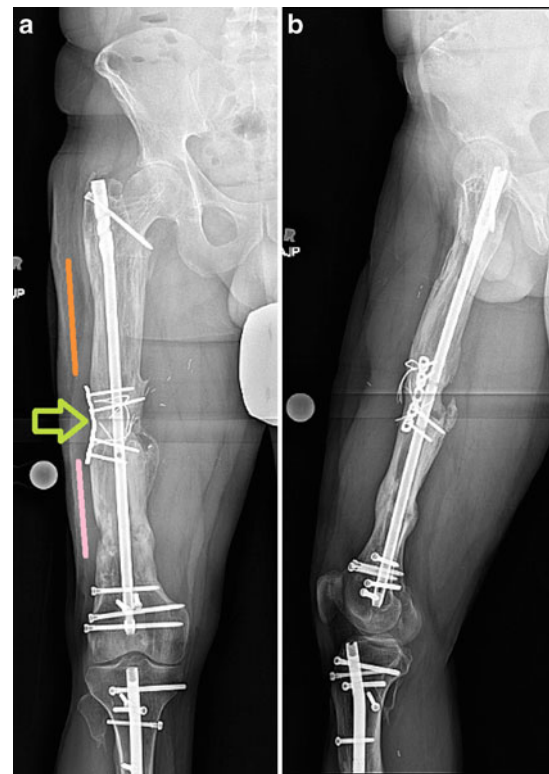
Final (a) AP and (b) lateral radiographs of right femur demonstrating 22-cm healed defect. Note the bony union of the proximal regenerate (orange line), distal regenerate (pink line), and the docking site (lime arrow)
